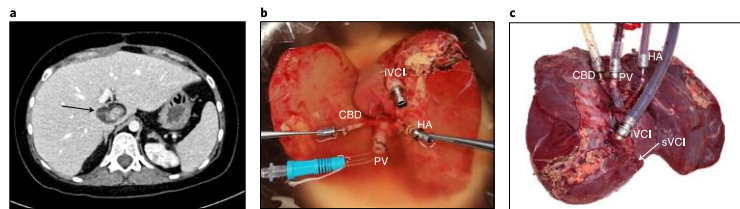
Donor liver shown on a preoperative CT scan, on the back table and during perfusion. a, CT scan of the donor liver displaying the tumor of unknown dignity (benign/malignant) in segment 1 (arrow). b, Donor liver on the back table. Flushing cannula in the portal vein (PV) during hypothermic perfusion with oxygenated MPS solution. Additional cannulas were placed in the hepatic artery (HA), the infrahepatic vena cava inferior (IVCI) and the common bile duct (CBD). c, Donor liver during ex situ normothermic machine perfusion. Cannulas were placed in the PV, the HA, the IVCI and the CBD. The suprahepatic vena cava inferior (sVCI) was temporarily sutured.
